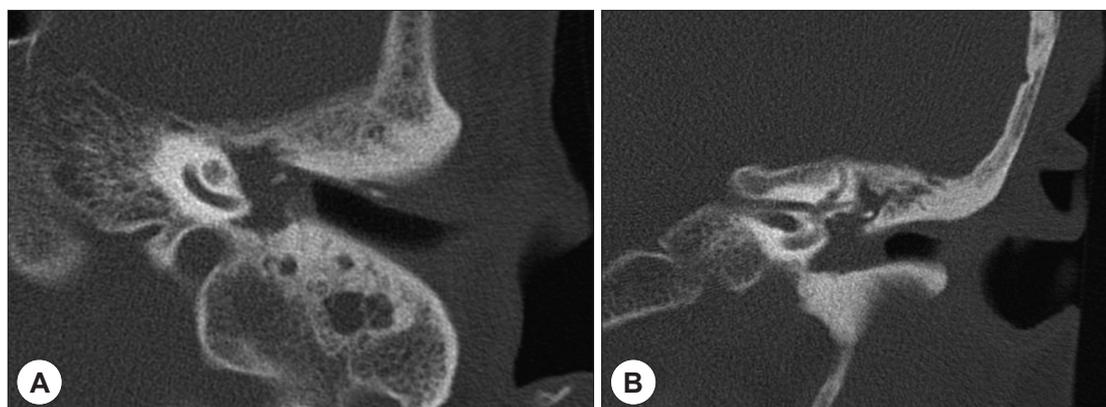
Temporal bone CT showed soft tissue density occupying the whole middle ear and medial part of ear canal. There is a total opacification of sclerotic mastoid. Ossicle erosion is suspected (A : axial view, B : coronal view).
